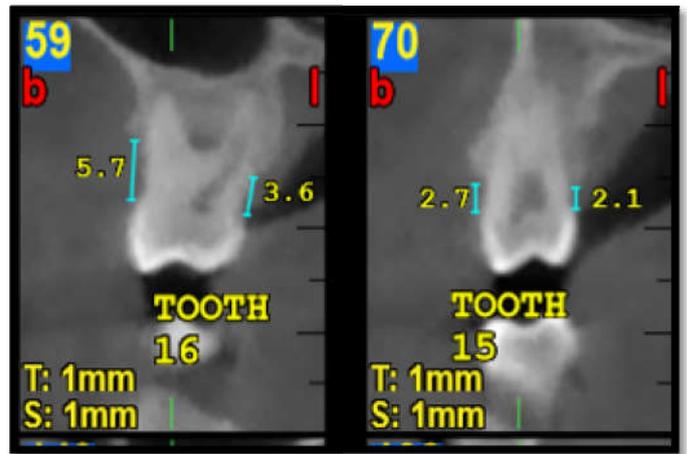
Post OP 6 Months CBCT IBD measurements
